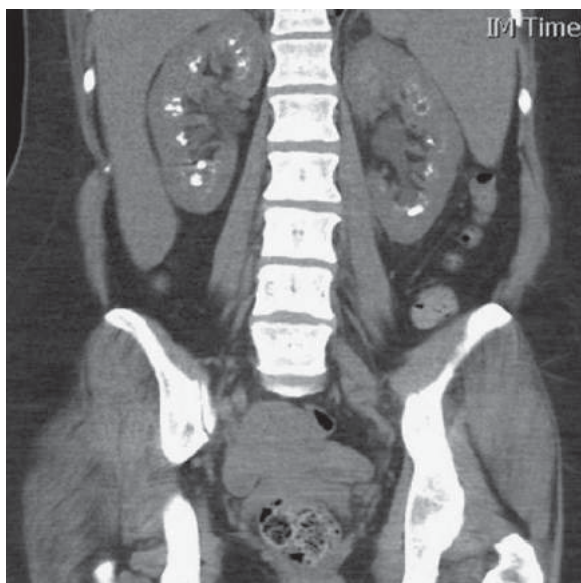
CT shows bilateral renal parenchymal calcific foci confined to the medullary areas.
